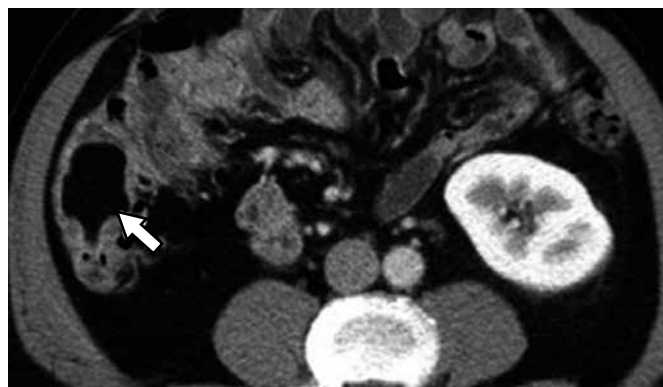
CT. Axial cut: Low density image, located in the wall of the colon that corresponds to lipoma (arrow).
